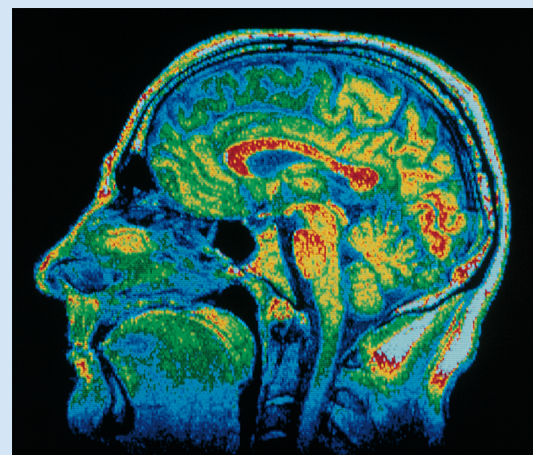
This falsely colored MR image of a human head shows the brain (sagittal section, see fig. 1.23). CNRI/SPL/Science Source
